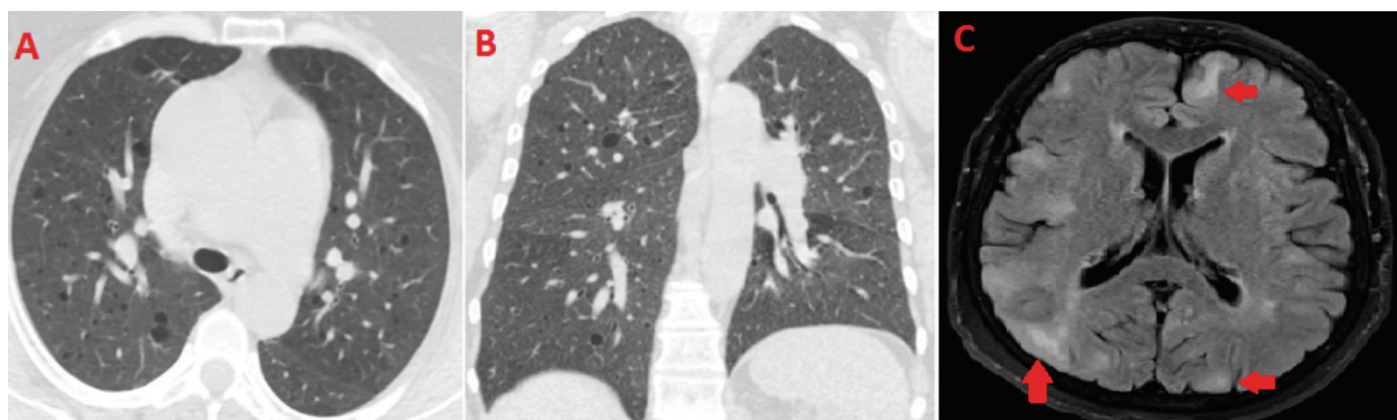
A) In high-resolution CT (HRCT), multiple thin-walled cysts are observed in both lung parenchyma (lymphangioleiomyomatosis). B) Lymphangioleiomyomatosis in HRCT (coronally section). C) In cranial MRI, cortical tubercles are seen as hyperintense in the T2 FLAIR sequence and shown with red arrows
